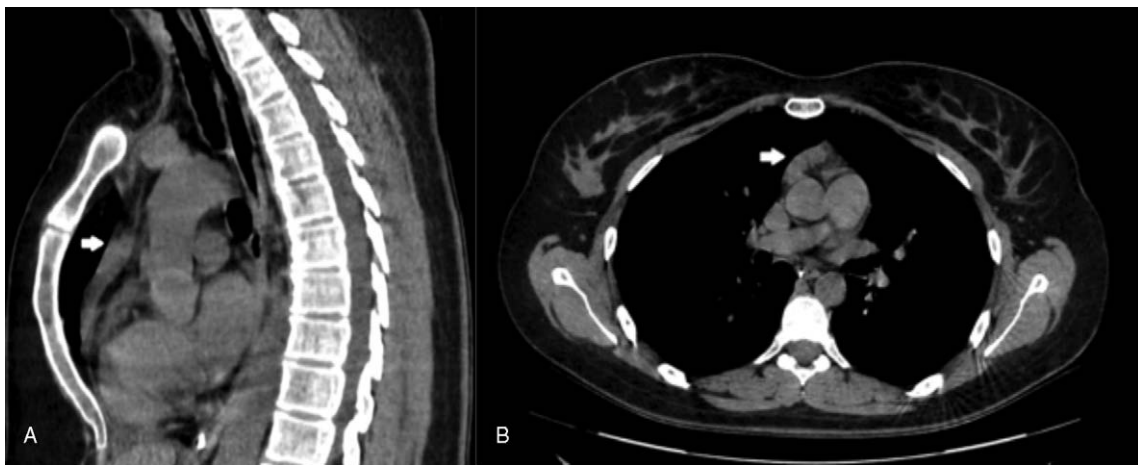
Axial (A) and sagittal (B) chest computed tomography with thymic remnant.
